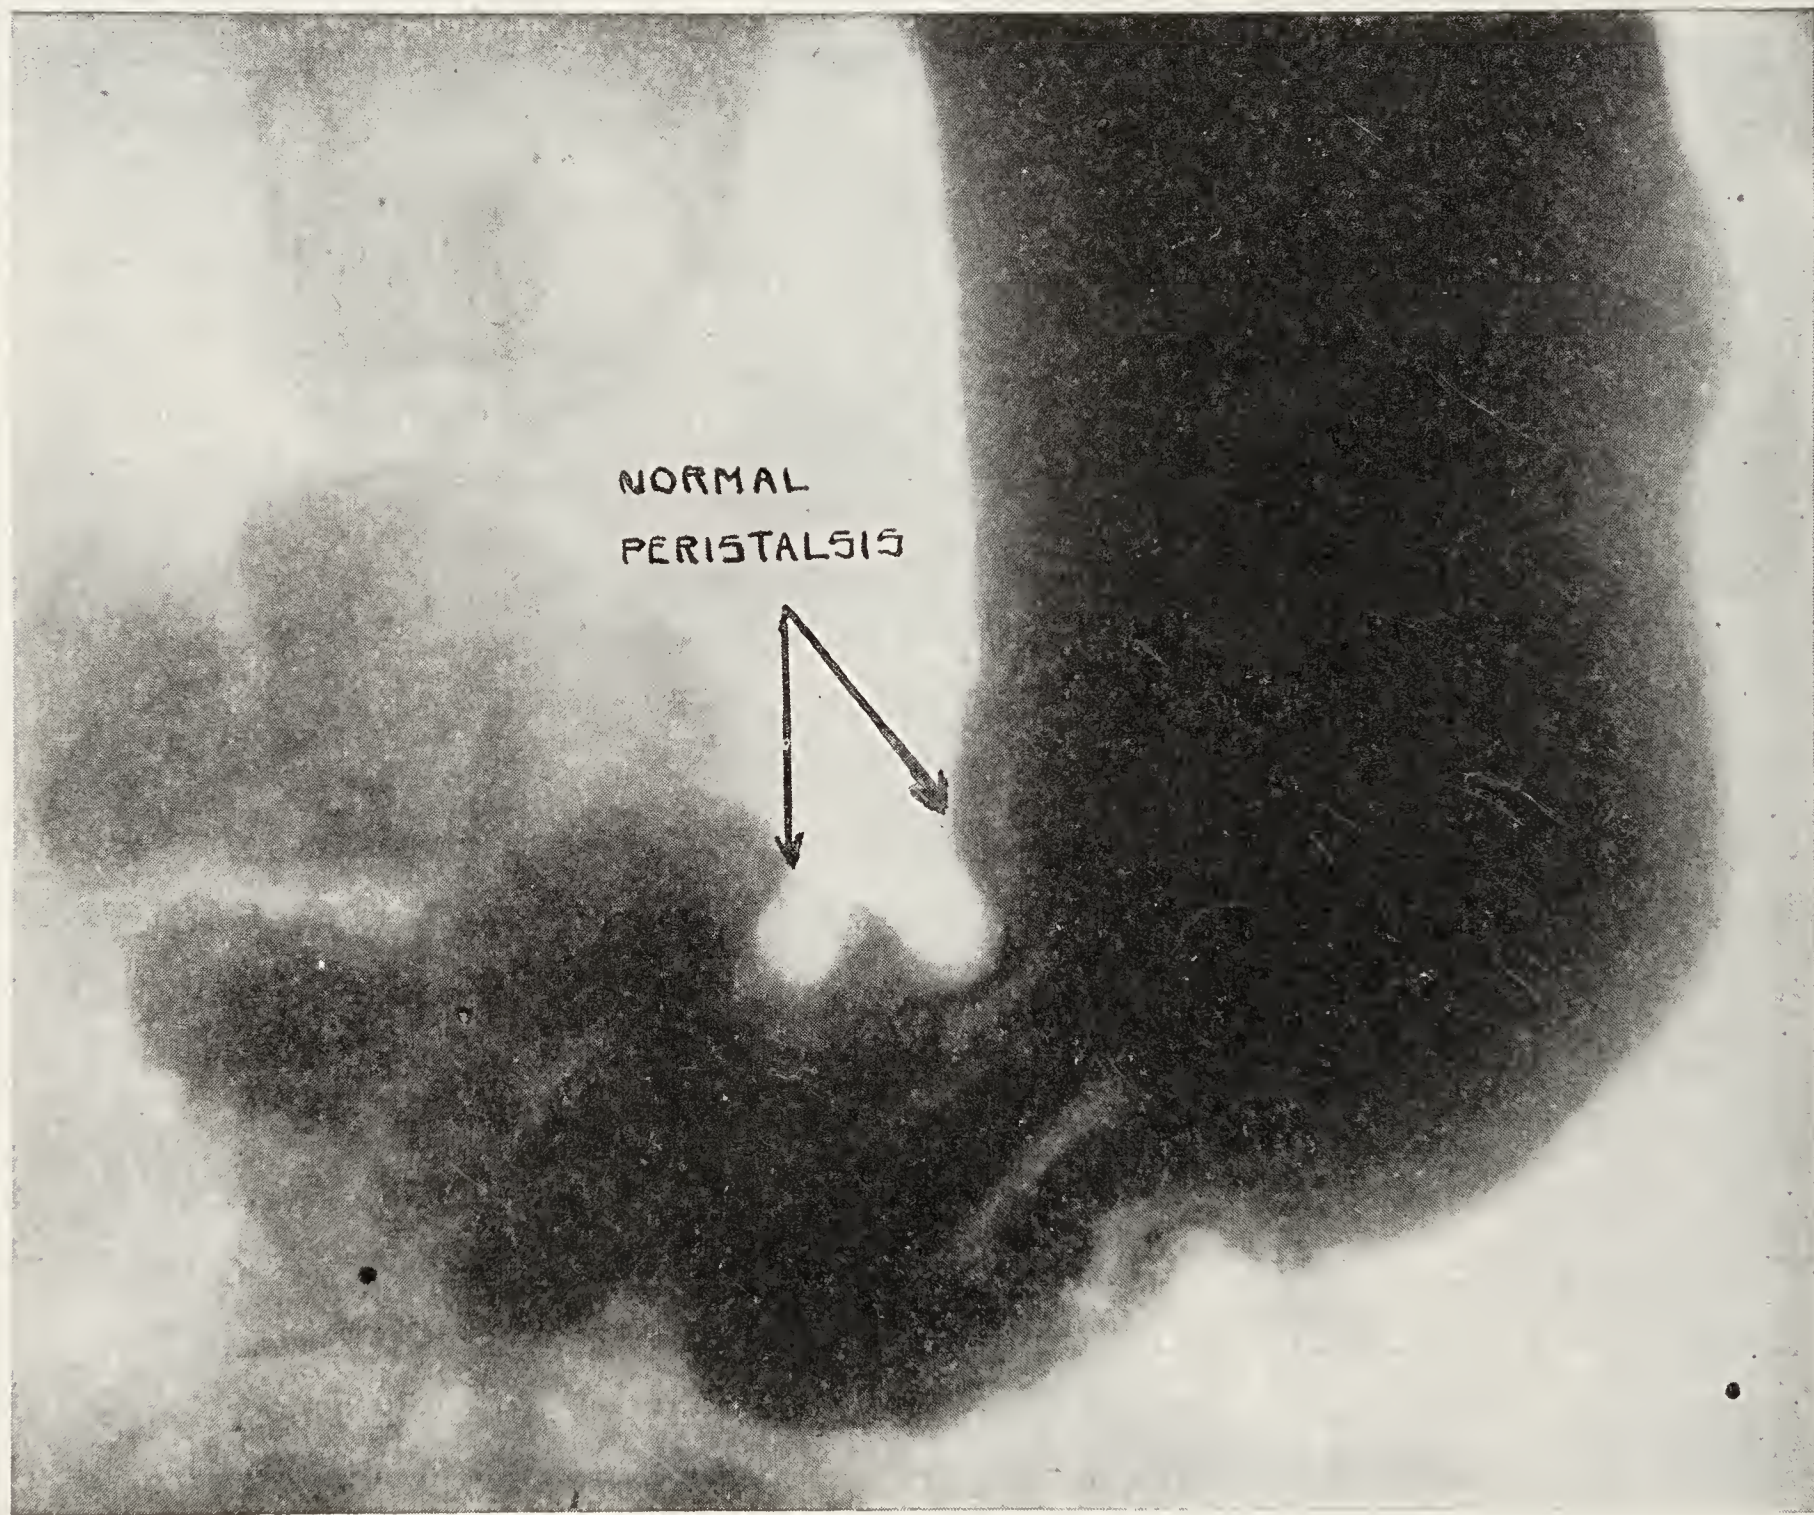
Normal Peristalsis, Resembling Indurated Ulcer. (*Lewis Gregory Cole, in American Journal of Roentgenology, November, 1915.*)
